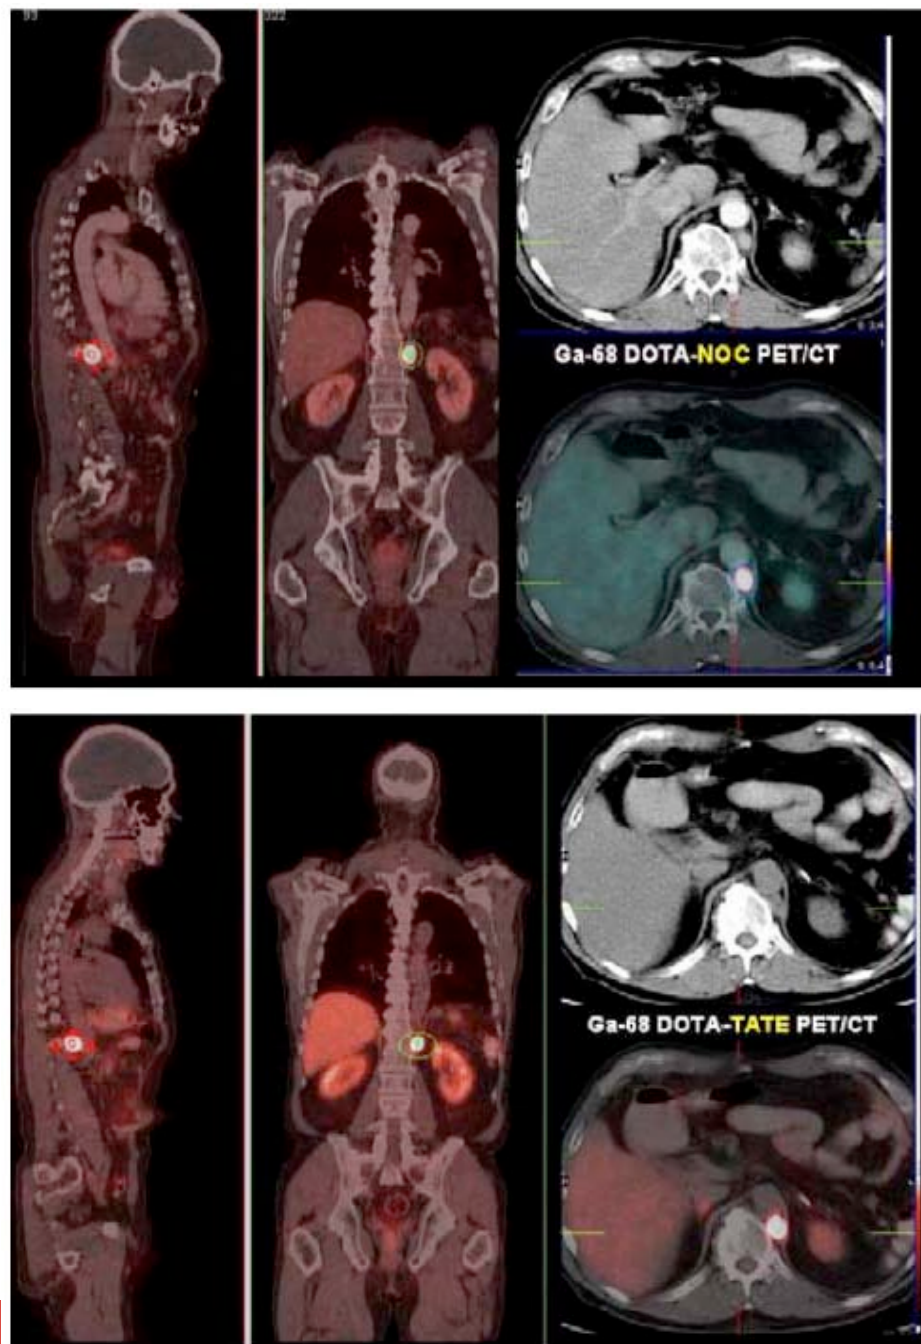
Comparison between ^{68}Ga -DOTA-NOC and ^{68}Ga -DOTA-TATE in the same patient (with a metastatic neuroendocrine pancreatic tumour), along with an ^{18}F -FDG PET/CT scan. The first whole-body PET/CT study (Siemens biograph duo) was performed after i.v. injection of 85 MBq ^{68}Ga -DOTA-NOC and revealed very intense uptake (SUV_{max} of 152) in a left retrocrural lymph node metastasis (A). In addition, a liver metastasis (about 10 mm in diameter on MRI) in the right inferior liver segment (S VI) (SUV 11.6, C: a) and a very small parapancreatic lymph node metastasis (C: c) were detected. The second PET/CT scan was performed 3 weeks later after i.v. injection of 130 MBq of ^{68}Ga -DOTA-TATE. Again, very high uptake (SUV_{max} 103) was seen in the retrocrural metastasis (B), but no other lesions were detectable (C: b,d). There was no increased glucose metabolism (normal ^{18}F -FDG PET/CT, D) in any of the lesions shown by receptor PET/CT
